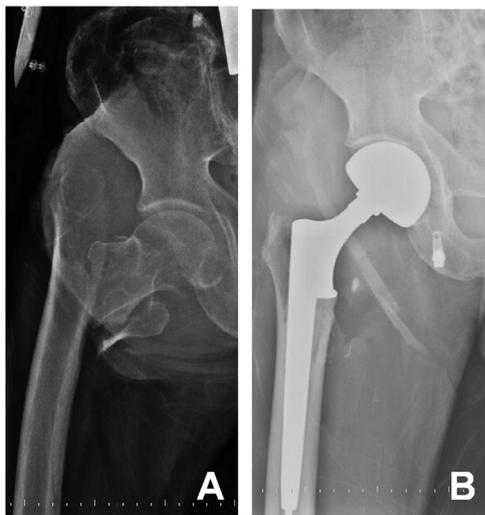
(A) A 75 years old female patient with an unstable Muller 31A2 intertrochanteric fracture. (B) Anteroposterior radiograph showing cemented calcar-replacement bipolar hemiarthroplasty prosthesis with a rectangular shaped collar.
